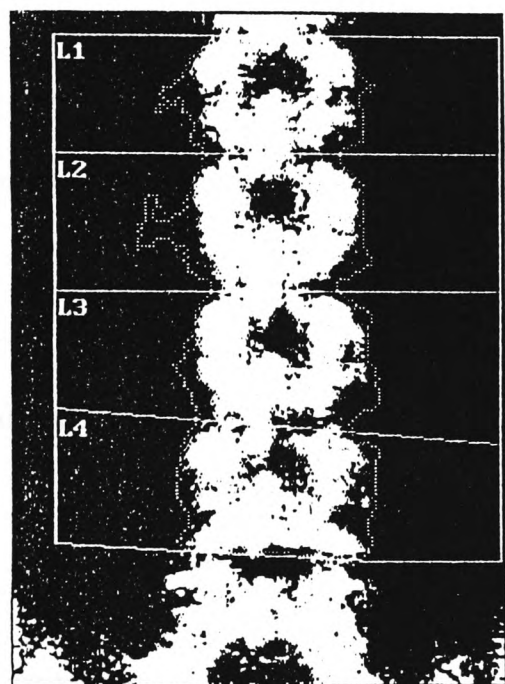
Radiograph of lumbar spine.
